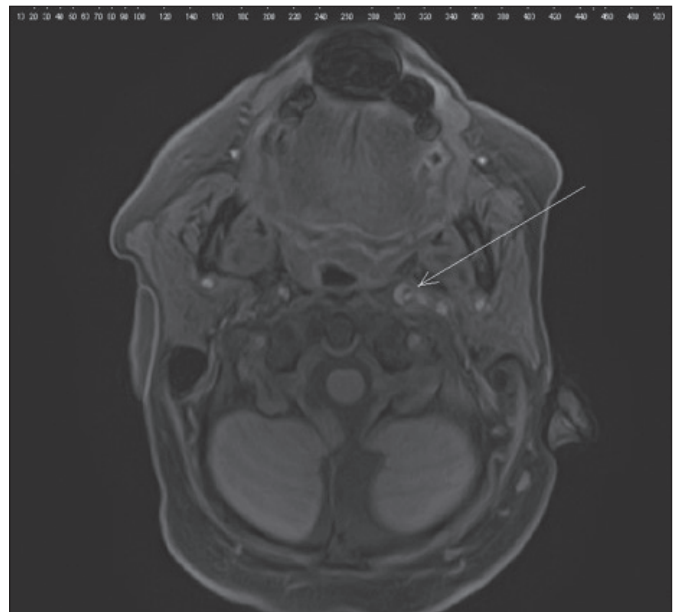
MRI FLAIR sequences. Semilunar aspect of the intramural hematoma.
